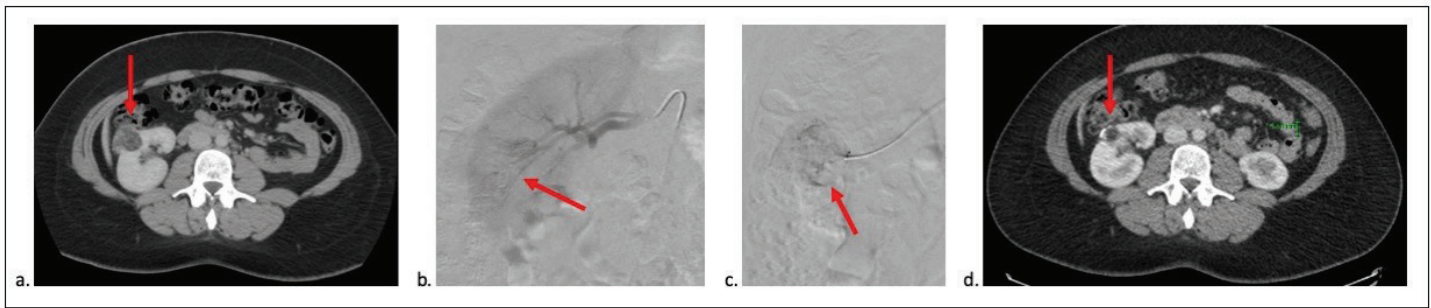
Imaging in 42-year-old female with hyperthyroidism status/post thyroidectomy and biopsy proven 3.9-cm AML. *a*, pre-operative CT with intravenous contrast enhancement demonstrates right inter-polar AML (arrow). *b*, DSA shows AML (arrow). *c*, DSA with selective catheterization of artery to AML (arrow). *d*, 4-month follow-up CT with intravenous contrast material without enhancement of now 2.2-cm AML (arrow).
